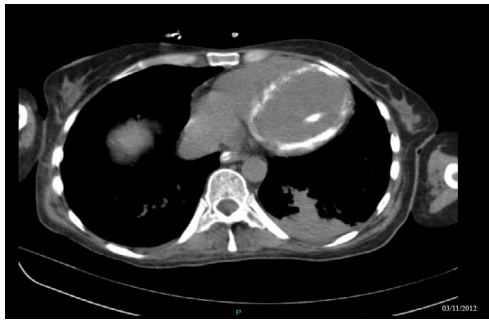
Computed tomography scan performed on day 25 after the ICU admission showing a diffuse left ventricular calcification.
